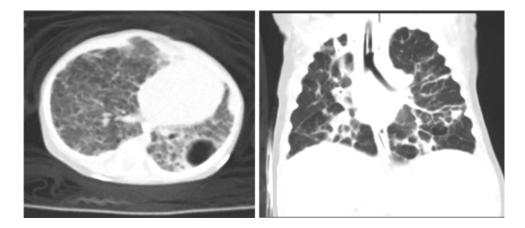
Evaluating lung parenchyma disease with CTA. *Left*: severe BPD with bulla (*arrow*); *right*: another BPD patient with intercostal bulging and parenchymal bands (*arrow*)
